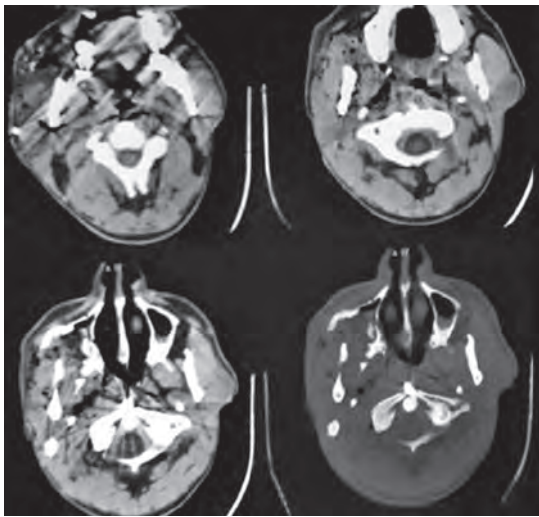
CT showing splinter lodged at the anterior tubercle of atlas
